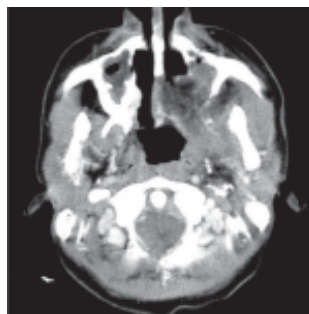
CT scan showing disease extension through posterior wall of left maxilla and eroding the pterygoid plates
